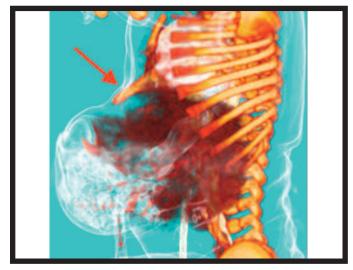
Volume Rendering 3D CT image (left oblique view) showing omphalocele sac and ectopia cordis (red arrow)
